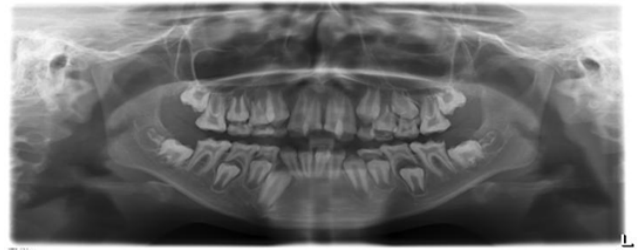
Panoramic radiograph showed presence mixed dentition present with a thin layer of enamel with radio density of enamel more than dentin, Enlarged pulp chambers
